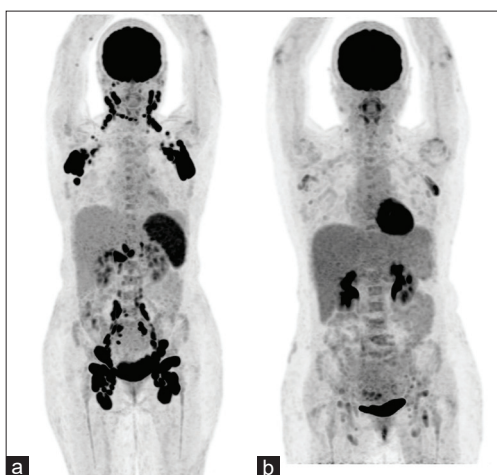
Comparison of the maximum intensity projection images of successive ^{18}F -fluorodeoxyglucose positron emission tomography/computed tomography performed three months apart. The first ^{18}F -fluorodeoxyglucose positron emission tomography/computed tomography (a) showed markedly fluorodeoxyglucose-avid bilateral cervical, bilateral axillary, abdominal, and pelvic (porta hepatis, paraaortic, paracaval, bilateral iliac and inguinal) lymphadenopathies. The second ^{18}F -fluorodeoxyglucose positron emission tomography/computed tomography (b) performed three months later showed interval metabolic improvement of the extensive lymphadenopathies
